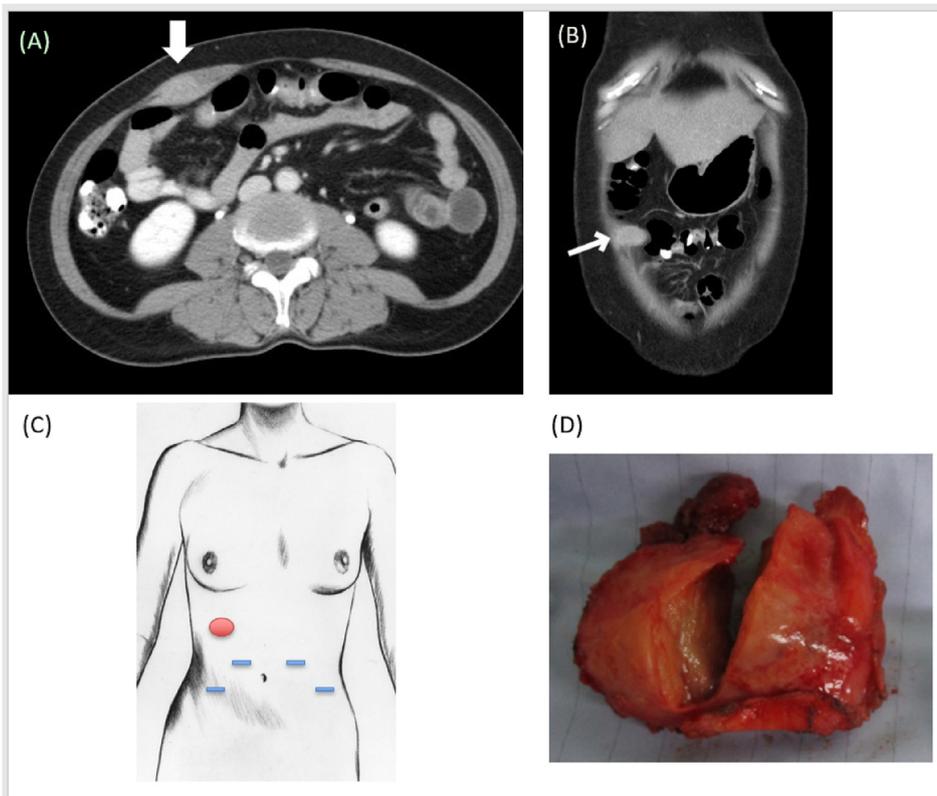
CT demonstrated a 2.5-cm intramuscular tumor inside the rectus abdominis muscle (arrow). (A) Axial view and (B) coronal view. (C) Tumor location: the tumor (red) was unrelated to previous laparoscopic trocar sites (blue). Source: <https://visualsonline.cancer.gov/details.cfm?imageid=1808>. (D) Cross section of the tumor: the tumor is well-circumscribed, tan, solid and firm.
